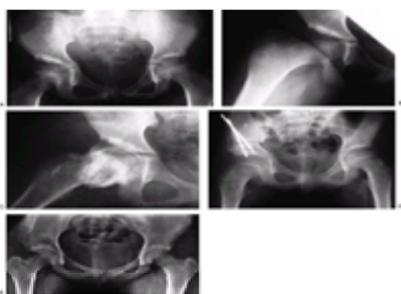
An 8-year-old white girl with residual right acetabular dysplasia. A: Anteroposterior (AP) radiograph of the pelvis. B: AP view of the pelvis with abduction, flexion, and slight internal rotation; the femoral head appears slightly uncovered. C: Similar view with the addition of an arthrographic dye. Note the excellent coverage of the proximal femur by unossified acetabular cartilage. D: Immediately after the innominate osteotomy. E: Four years after the innominate osteotomy.
